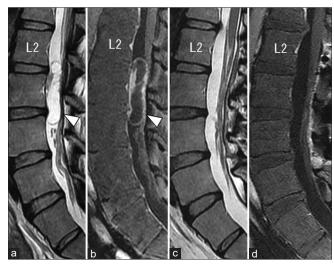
The mid-sagittal view of lumbar MR images before (a and b) and after (c and d) the first surgery. Preoperative T2-weighted (a) and Gd-enhanced T1-weighted (b) images demonstrating intradural cystic tumors at the L2-4 level (white arrowhead). Postoperative T2-weighted (a) and Gd-enhanced T1-weighted (b) images showing no residual tumor.
